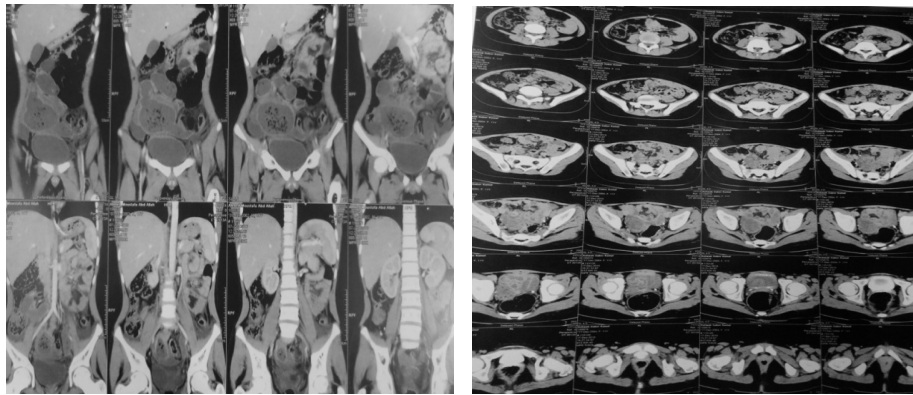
CT scan of 2 patients with YSTs (coronal & axial views) showing the fat content of the right ovarian mass.
